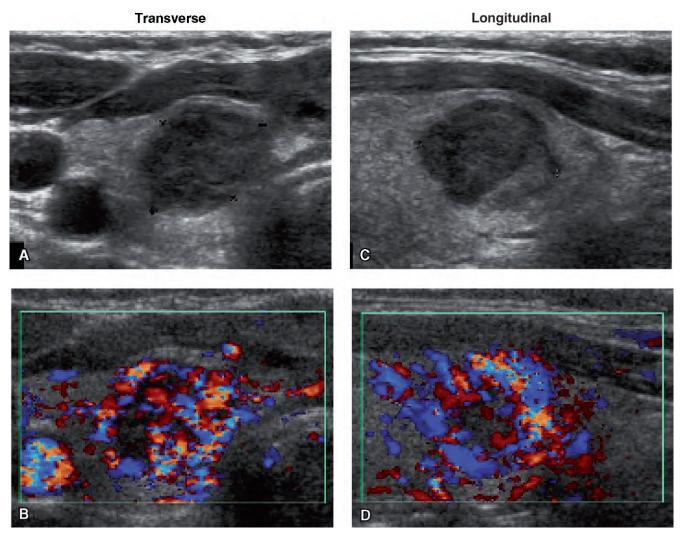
Ultrasound of follicular variant of papillary thyroid carcinoma in the right lobe. A, Transverse, 10 x 14 mm. B, Color Doppler, transverse. C, Longitudinal, sagittal diameter: 14 mm. D, Color Doppler, longitudinal.
